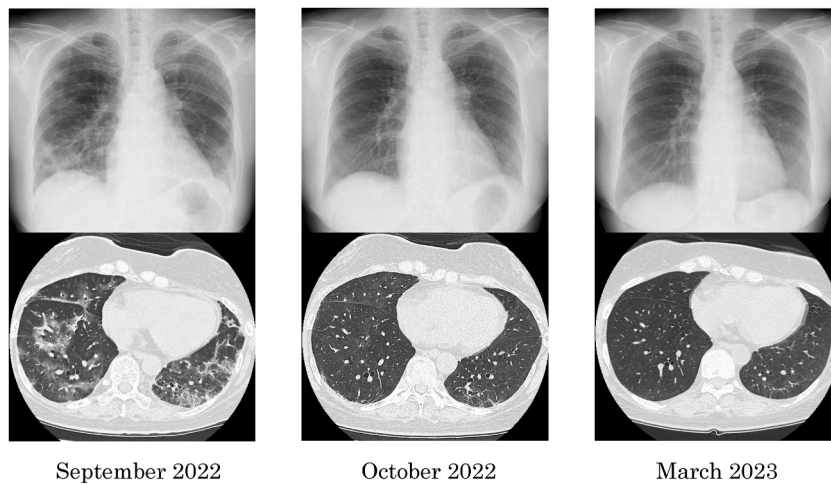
Chest radiography and computed tomography after hospitalization. Chest images obtained in September 2022 at the time of admission. Remarkable improvement is observed in October 2022, and ground-glass opacities completely disappeared in March 2023.
